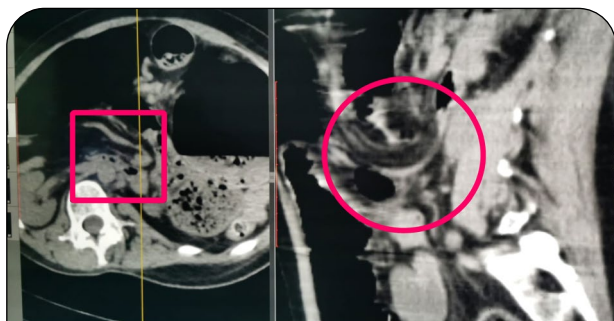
Abdomen ultrasound, transversal and sagittal section. Direction changes of the upper mesenteric vessels.
